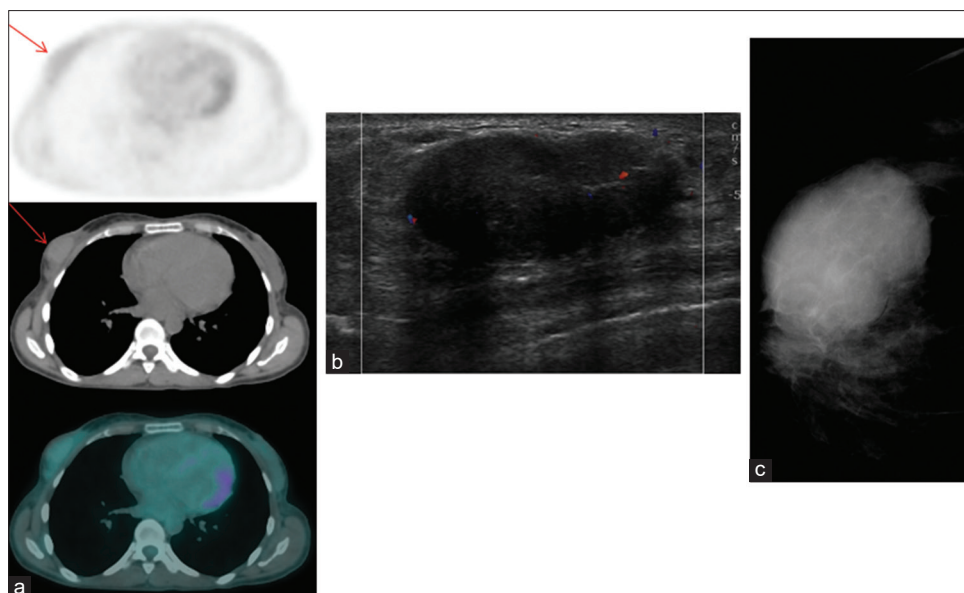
A 45-year-old female with a history of gastrointestinal stromal tumor; restaging positron emission tomography/computed tomography revealing mild hypermetabolic mass in the right breast (red arrows, a), ultrasound revealing a well-defined solid hypoechoic nodule (3.7 cm × 2 cm × 3.2 cm) with minimal vascularity (b) seen also on mammogram (c). → The patient mentioned that she had the mass for over 18 years suggestive of benign etiology/fibroadenoma
